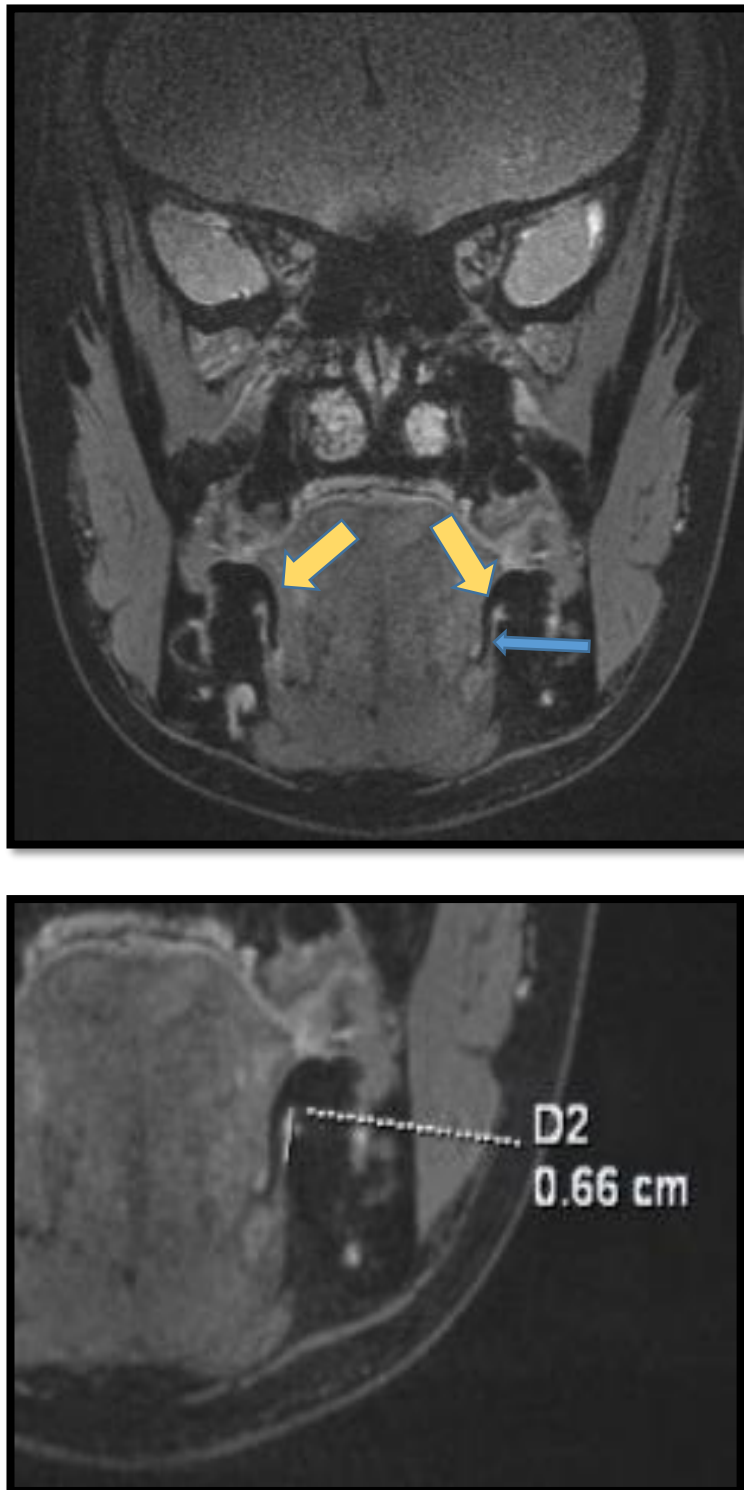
7 MRI coronal view of T2 3D-DESS WE at the level of an erupted third molar region,(point B) notice the intra-oral separator(yellow arrow) and the identified lingual nerve on the right side at point B this was measured to be 0.66 cm (6.6 mm).
